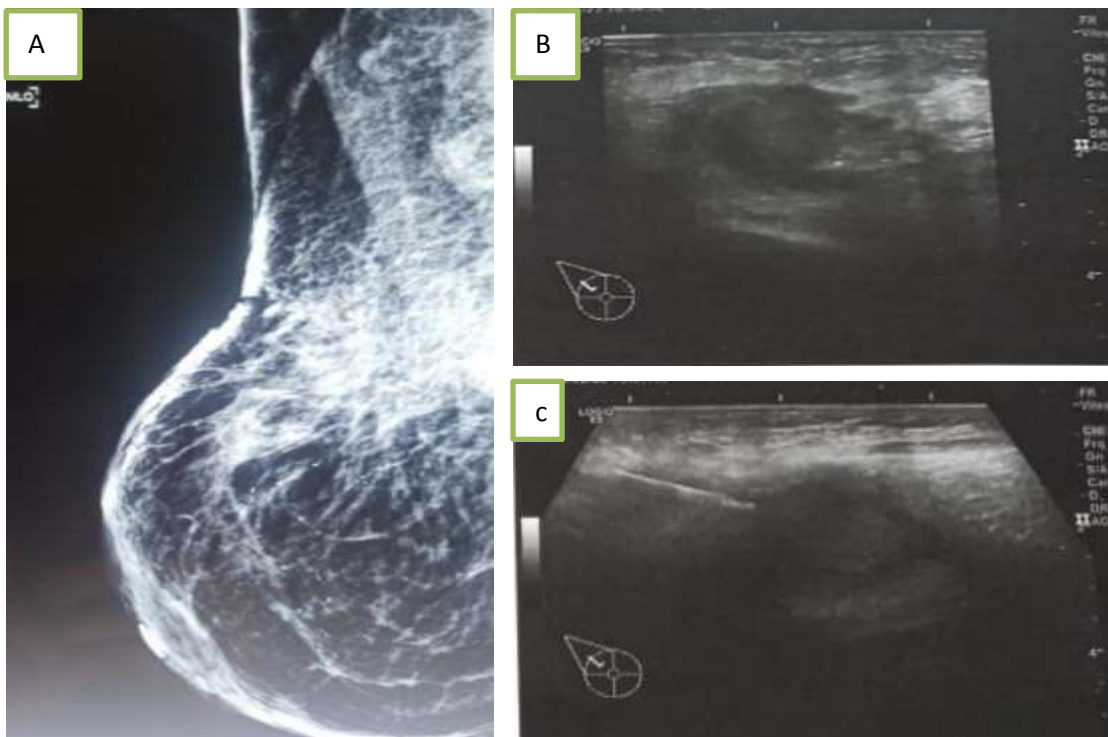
The mammography (a) and the ultrasound (b, c) showed a mass of the external quadrant, containing some liquefaction zones with fistulous path directed anteriorly towards the subcutaneous tissue and continued posteriorly by a hypoechoic band towards the pleura with and axillary adenopathy
